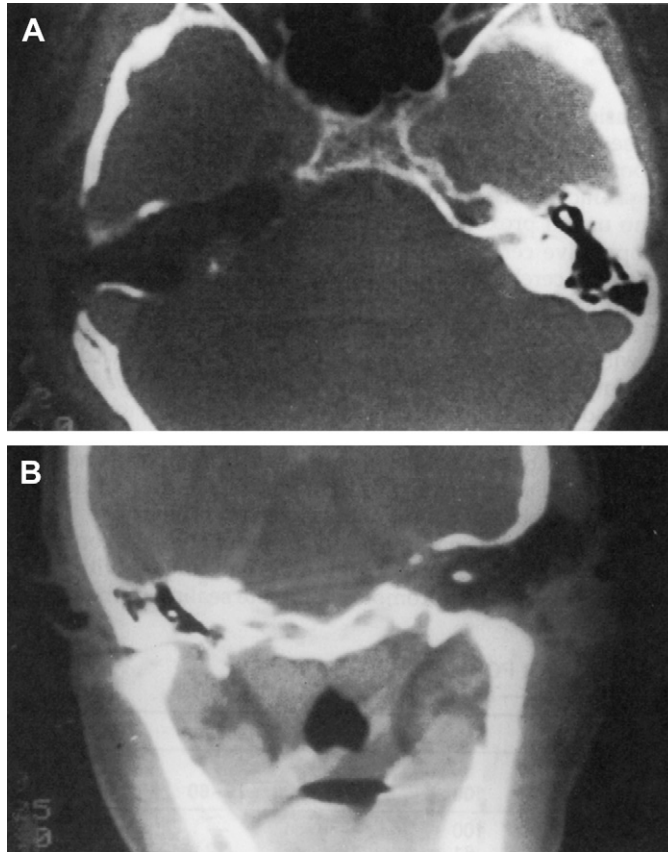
Postoperative computed tomography scan following a transotic approach to the cerebellopontine angle for tumor removal. Note the wide exposure and bony defect created in the medial temporal bone. (A) Axial view. (B) Coronal view.
